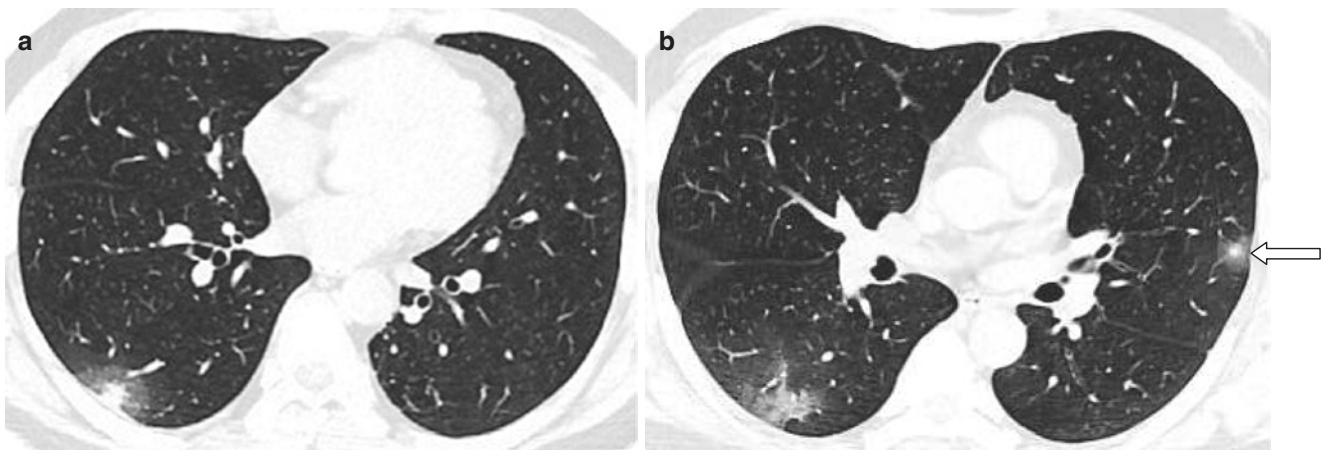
(a) A 56-year-old male patient. CT scan shows ground-glass opacity in both lungs, with unclear boundary. Some lesions were pulled near the pleura. The stripe shadow can be seen (empty arrow). The lesions are mainly distributed in the pleura. (b) A 56-year-old male
